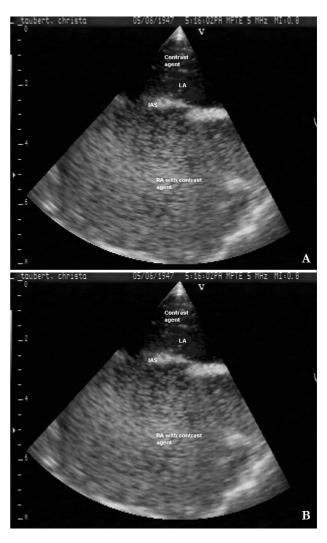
Transesophageal echocardiography before (A) and after (B) application of contrast medium. (B) showes right-to-left shunt (IAS = interatrial septum, LA = left atrium, RA = right atrium).
